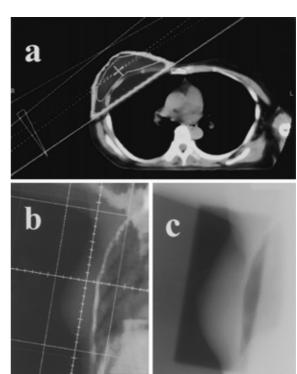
Irradiation techniques using the CT-based radiation therapy planning system
